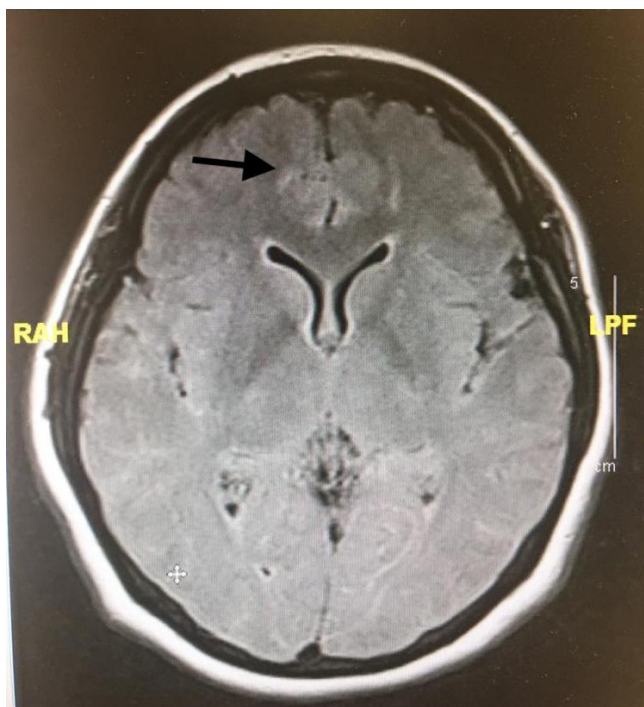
MRI brain at T2/FLAIR showed hyperintensities at bilateral frontal lobes (arrow)
